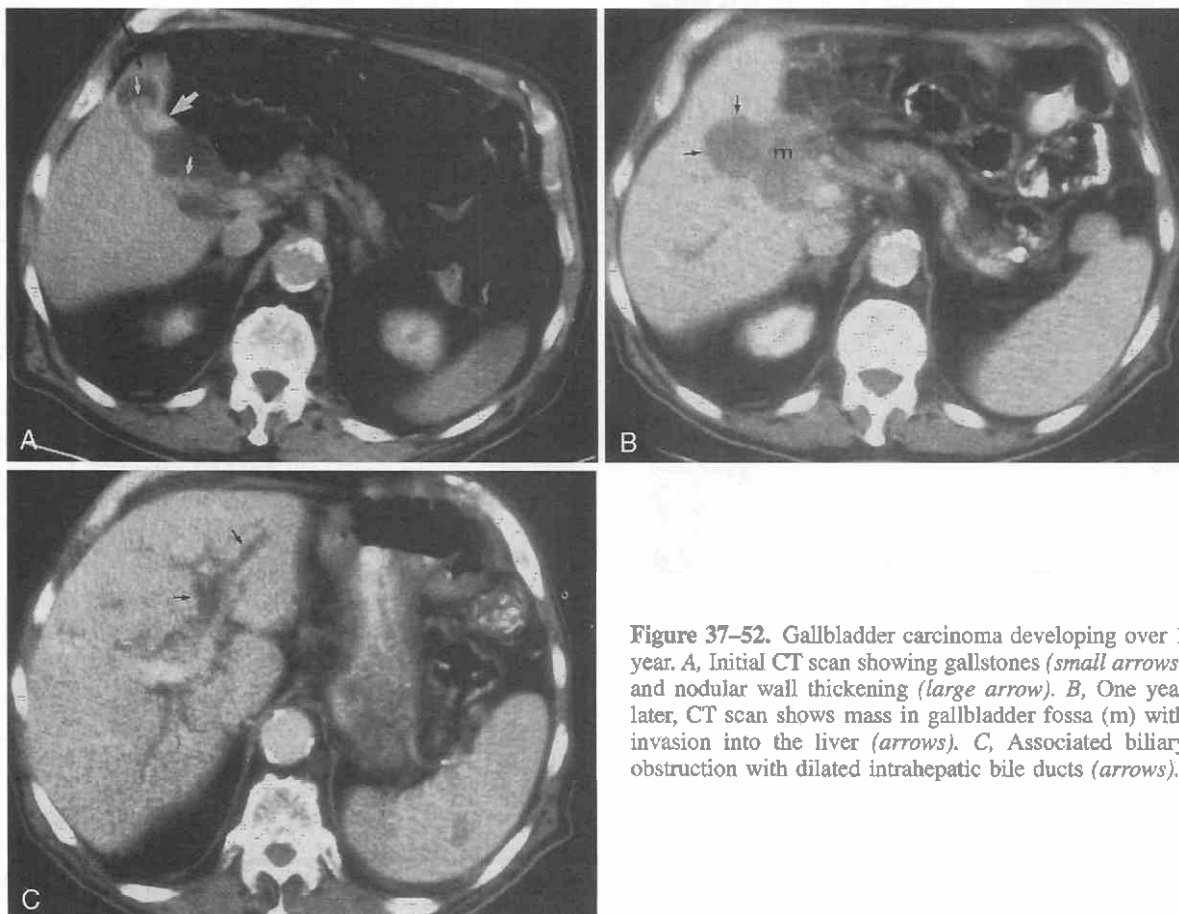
Gallbladder carcinoma developing over 1 year. A, Initial CT scan showing gallstones (*small arrows*) and nodular wall thickening (*large arrow*). B, One year later, CT scan shows mass in gallbladder fossa (m) with invasion into the liver (*arrows*). C, Associated biliary obstruction with dilated intrahepatic bile ducts (*arrows*).
